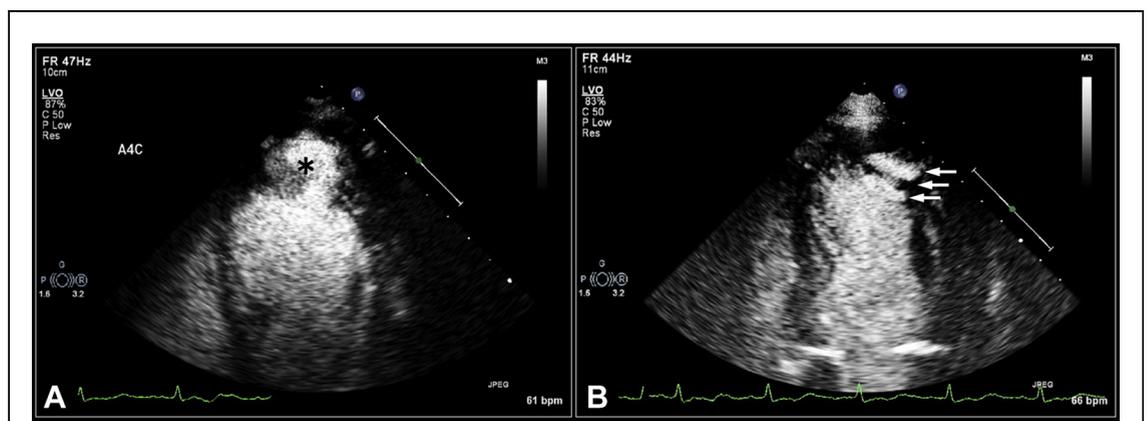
Transthoracic Echocardiogram With Contrast (Apical 4-Chamber View)
